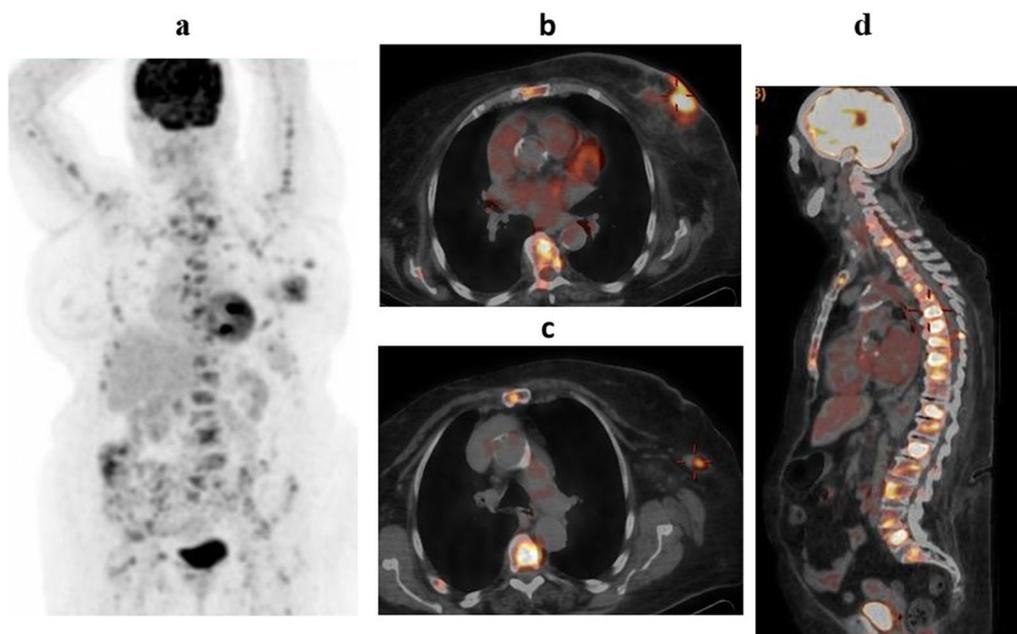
A female patient aged 84 arrived with newly diagnosed left breast cancer (IDC grade III). a Whole-body PET MIP image revealed active left breast and left axillary lesions with other innumerable skeletal active lesions. b Axial fused PET/CT picture revealed an ill-defined irregular metabolically active left breast retroareolar soft tissue mass lesion with maximal axial dimensions of 43 × 25 mm and SUVmax of up to 7.33, coupled with modest overlaying skin thickening and surrounding architectural distortion. c Axial fused PET/CT image revealed enlarged metabolically active left axillary lymph node, measuring 11 × 7.5 mm and achieving up to 5.19 SUVmax. d Sagittal fused PET/CT image revealed innumerable hypermetabolic osseous lesions at the spine, achieving up to 10.41 SUVmax
